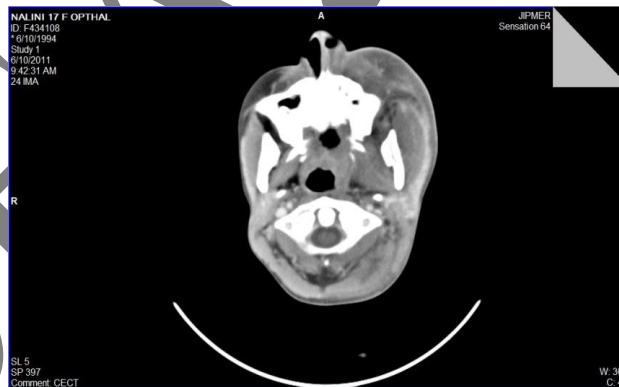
CT scan showing Soft tissue density with an air fluid level in left temporal, infratemporal and left masticator space.
